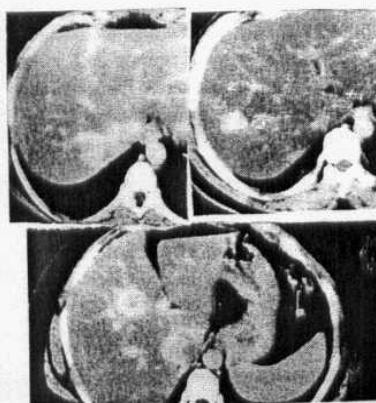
CTA demonstrates the lesion as hyper dense on a back ground of relatively hypo dense liver parenchyma.
